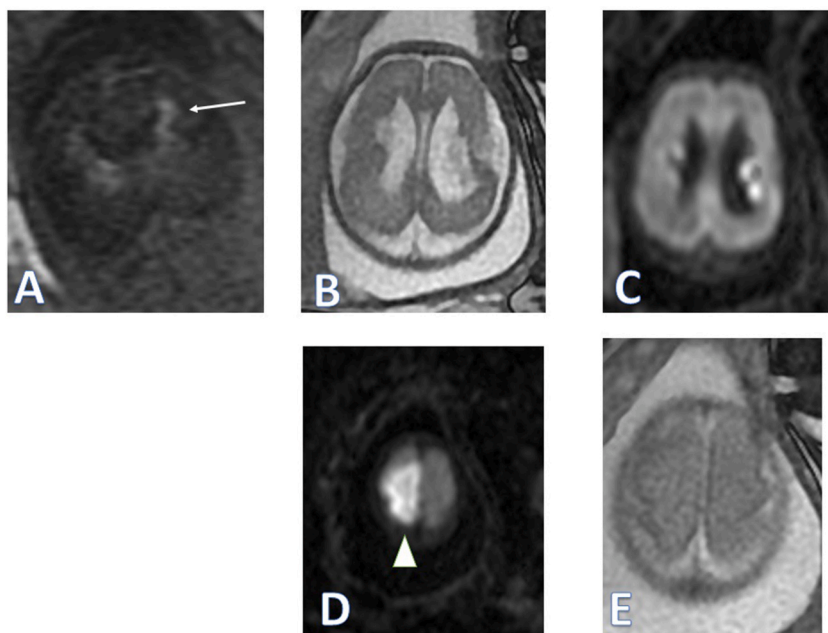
A 28-GW singleton pregnancy. The GM-IVH components (arrow) were detected on T1WI (A), T2WI (B) and DWI (C). On the upper plane, a patchy high signal (arrowhead) indicating early cerebral infarction in the frontal-parietal lobe was also displayed on DWI (D), which did not show any abnormal signal on the corresponding T2WI (E).
